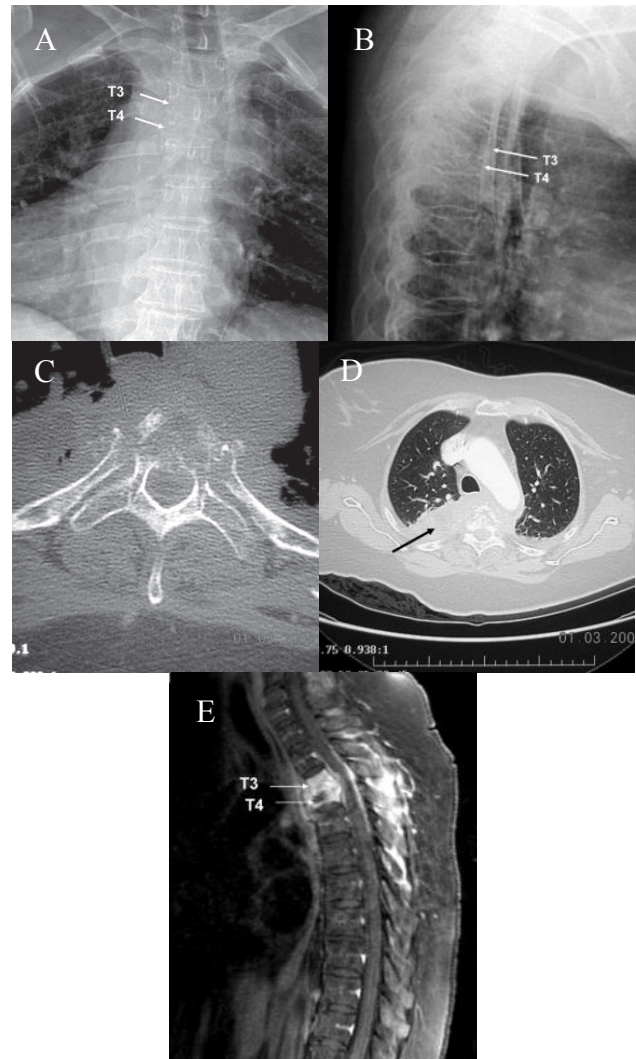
Preoperative images of the thoracic spine of a 68-year-old female patient who presented with a one-month history of progressive upper back pain and paresis. The AP (A) and lateral (B) radiographs show kyphotic collapse of the T3 and T4 vertebral bodies and intervening disk space. The CT scan (C and D) shows the lytic destruction of the vertebral bodies and the presence of a paraspinal abscess that extends into the right mediastinum. Fat-suppressed MRI scan (E) shows inflammatory changes affecting the anterior and middle columns, and clearly demonstrates the extrinsic spinal cord compression caused by the abscess and retropulsed bone fragments.
